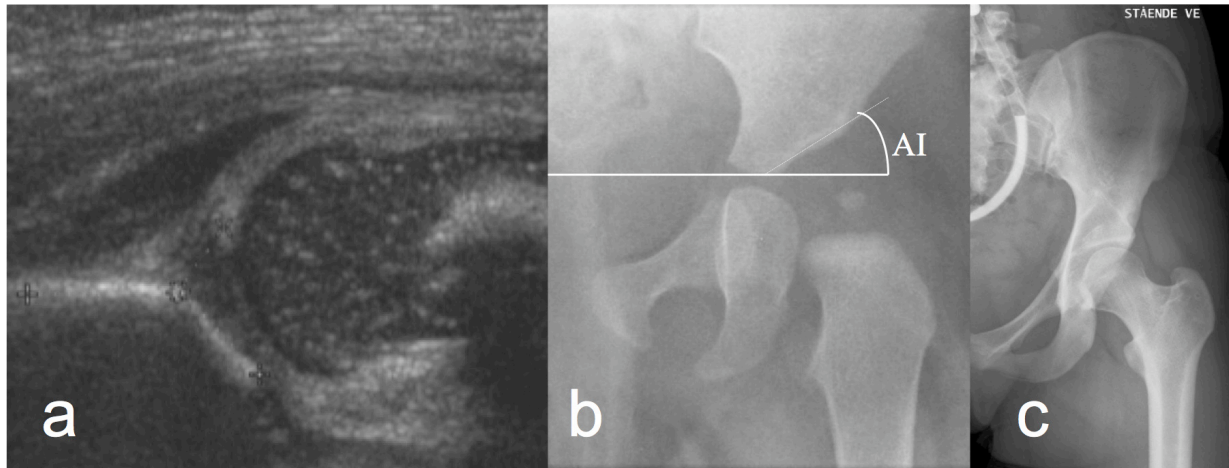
Ultrasound left hip in a newborn girl, showing a mildly dysplastic hip (a). A follow-up radiograph at four months of age shows a dysplastic acetabulum with a high acetabular index (AI) (b), while a pelvic radiograph at 18 years of age shows residual dysplasia (c).
